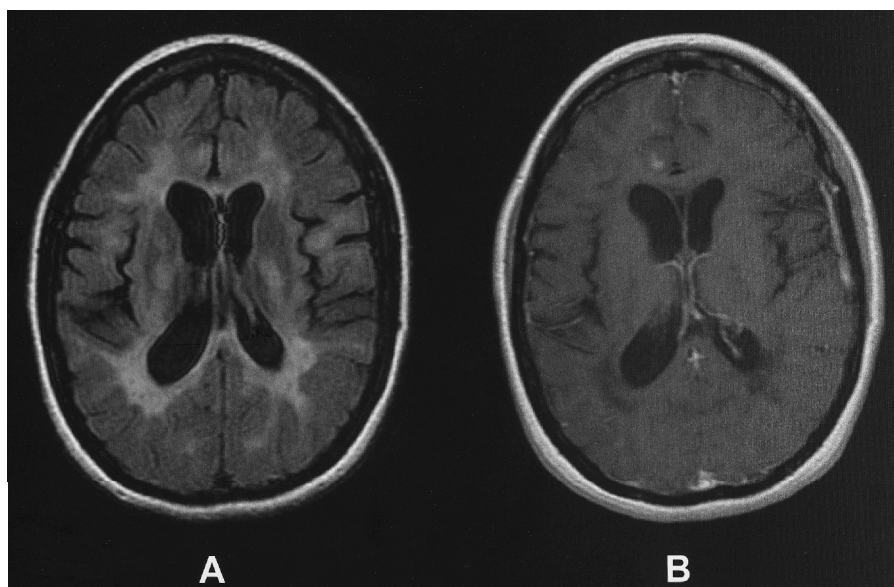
MRI scans of the brain of a 32-year old woman with RRMS. (A) An axial FLAIR (fluid-attenuated inversion recovery) image reveals multiple hyperintense lesions in the periventricular white matter. (B) A gadolinium-enhanced axial T1-weighted image of the same patient reveals an enhanced lesion, which is indicative of BBB disruption during active inflammation.
